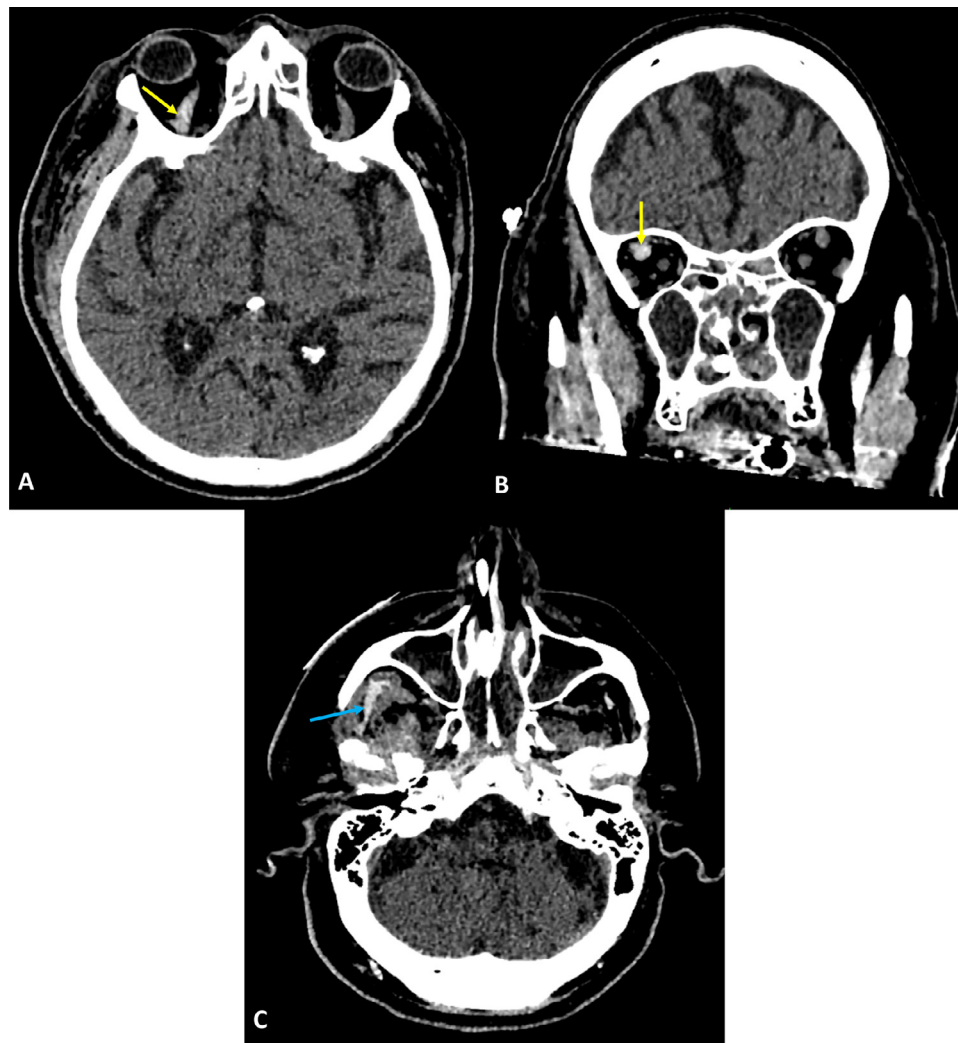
(A) Axial and (B) Coronal unenhanced CT head slices demonstrating a dilated asymmetrically hyperdense right SOV (yellow arrows) consistent with acute thrombosis. The left SOV also appears dilated, features of which are suggestive of bilateral CCF. (C) Axial CT image showing asymmetrical hyperdensity within the right masticator space (blue arrow), concerning for acute thrombosis within the right pterygoid venous plexus.
